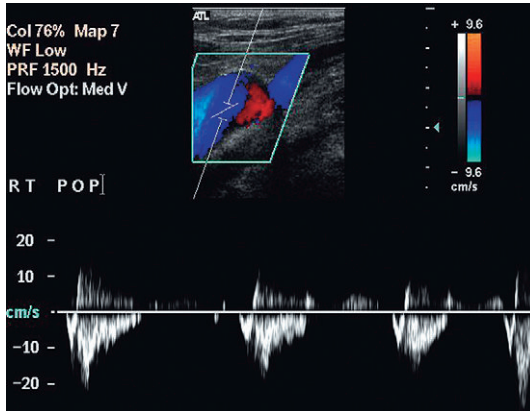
Turbulence in a vein showing both red and blue signal in the lumen on colour Doppler and simultaneous forward and reversed flow on the spectral display.
